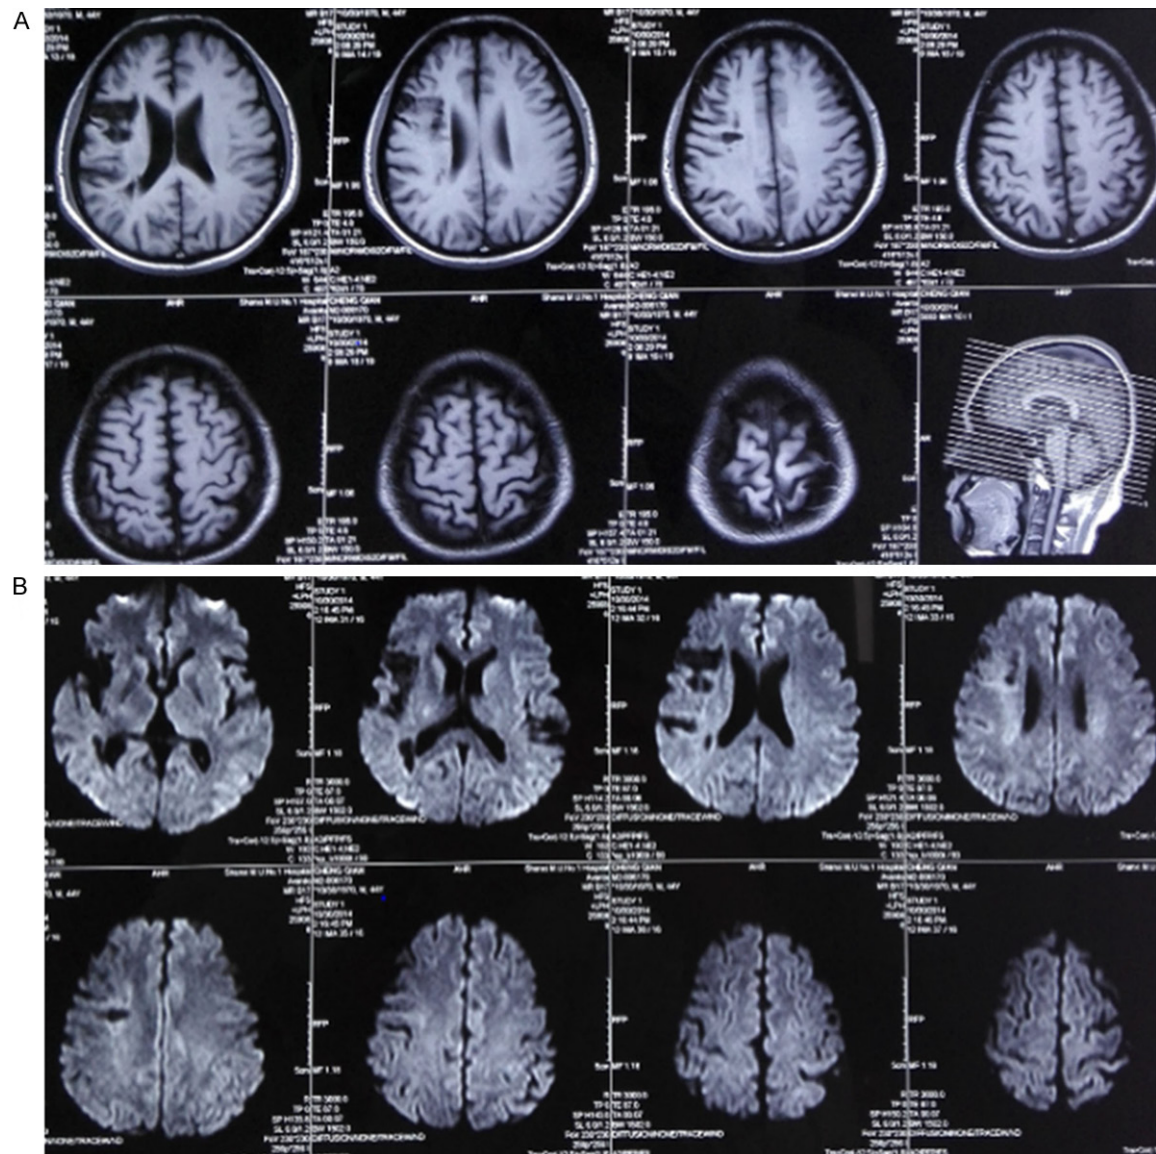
Cerebral MRI examination review (A. T1; B. DWI).
